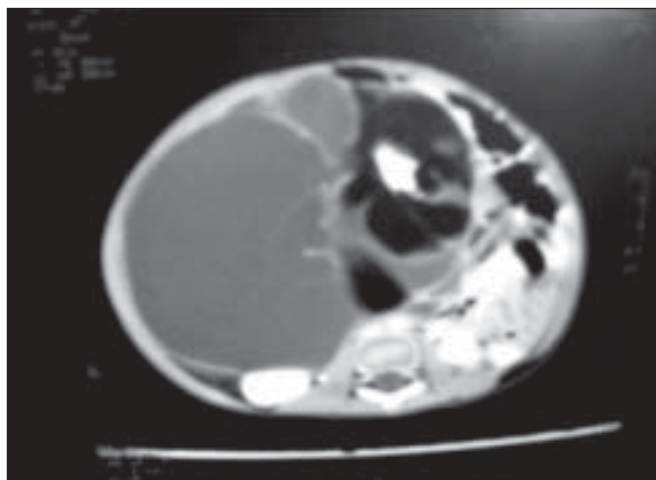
CT Scan of the abdomen showing a fairly large, multiseptate, cystic mass with eccentrically located areas of fat and calcification
